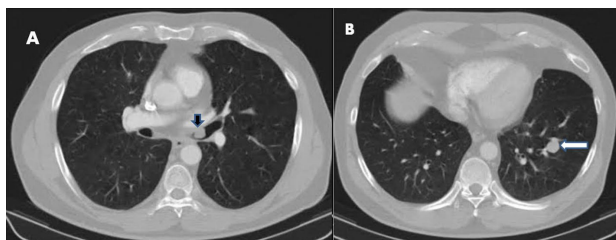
Axial CT image shows an endobronchial lesion within left main bronchus (A) (Arrow) and a parenchymal hamartoma in left lower lobe (B) (Arrow) in the same patient
